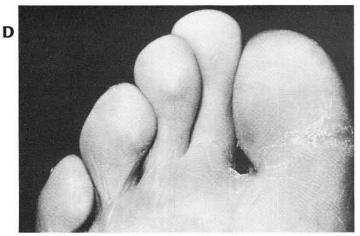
D, E. Six months postoperative clinical and radiographic appearance showing resolution of neurotrophic ulceration.
